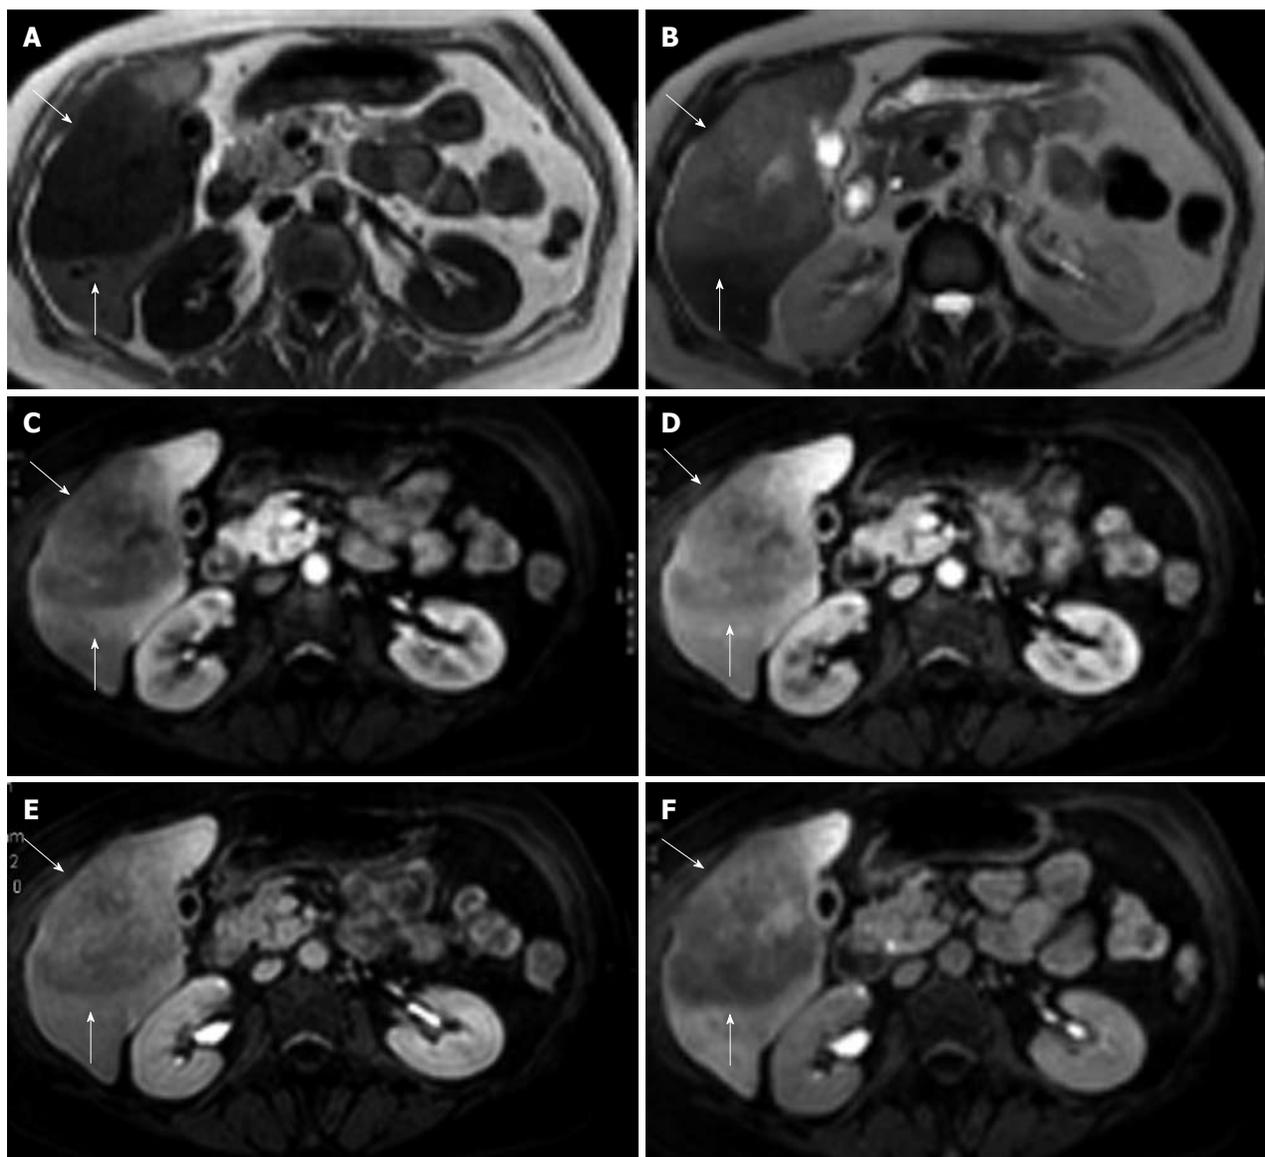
Magnetic resonance imaging showing a large, sharply demarcated lesion measuring 11 cm in the right liver lobe. The lesion is hypointense on T1 (A) and hyperintense on T2 (B) weighed images with slight inhomogeneity. Arterial (C), portal (D), equilibrium (E) and hepato-biliary (20 min) (F) phase magnetic resonance imaging after Gd-EOB-DTPA contrast enhancement reveal a hypovascular lesion without uptake in the hepato-biliary phase (lesion indicated by white arrows).
